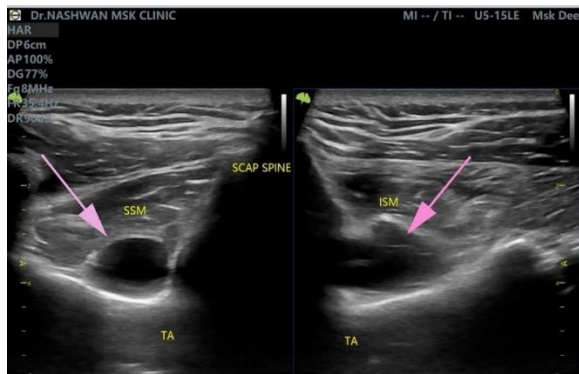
An ultrasound of the spinoglenoid cyst extended to the supraspinatus (SSM) and infraspinatus (ISM) muscles.
